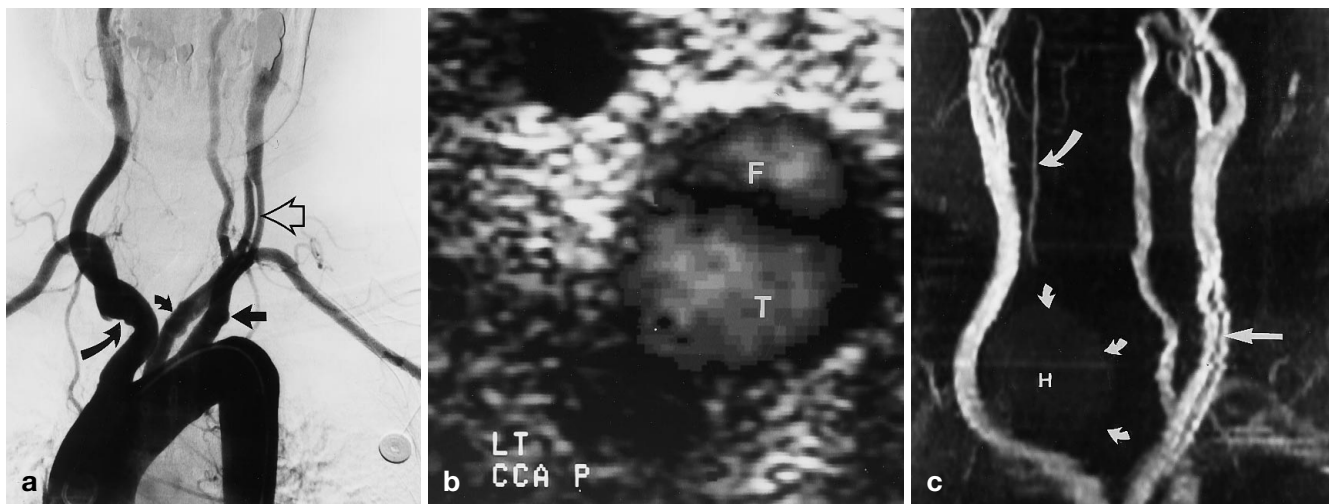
A 66-year-old woman suffered a high-speed motor vehicle accident during which her air bag inflated. An arch aortogram was performed. a A right posterior oblique image from an arch aortogram demonstrates an intimal flap in the left common carotid artery (*open arrow*), with flow in both true and false lumens. In addition, irregular outpouchings of contrast were noted involving the proximal subclavian artery (*straight solid arrow*), left common carotid artery (*short curved solid arrow*), and brachiocephalic artery (*long curved solid arrow*). These abnormalities were confirmed in other views. Additionally, the right vertebral artery was noted to be occluded proximally and to reconstitute distally via muscular collaterals. b A follow-up ultrasound study was obtained to assess flow in the left common carotid artery. Transverse images from a color Doppler study show flow in both the true (*T*) and false (*F*) lumens. c A coronal maximum intensity projection image from a 2-D time of flight MR angiogram similarly demonstrates the persistent intimal flap (*straight arrow*), with flow in both true and false lumens. In addition, a portion of the reconstituted right vertebral artery is seen (*long curved arrow*). Also noted is a faintly bright, rounded mass projecting superior to the right brachiocephalic artery (*short curved arrows*). This represents mild methemoglobin “shine-through” from a resolving traumatic thyroid hematoma (*H*)
